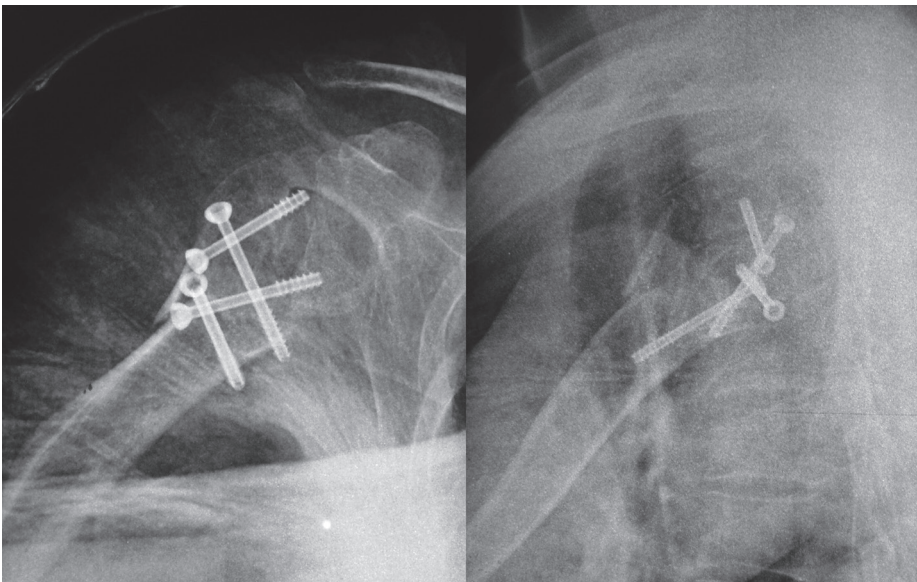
Anteroposterior and lateral position radiographs taken immediately after the operation, showing the head and greater tuberosity fragment with alignment restored and fixed with 4 annulated compression screws oriented in different directions
